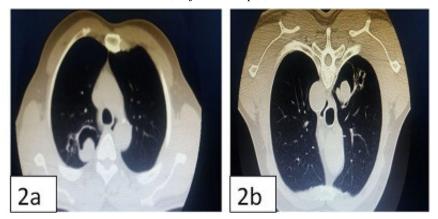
(a,b): HRCT thorax in supine and prone position shows a thin-walled cavity in the apico posterior segment of the right upper lobe with surrounding bronchiectatic changes. Homogenously hyperdense mass lesion noted within the thin-walled cavity. Mass lesion shows postural variation within the cavity (gravity dependent variation of mass in supine and prone position)
